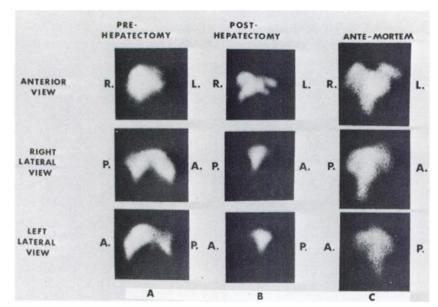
Typical technetium-sulfur colloid scintigraphs. Three views obtained (A) before partial hepatectomy. (B) immediately after partial hepatectomy, and (C) before sacrifice (in this case 22 days posthepatectomy). Note removal of anterior lobes is best seen in lateral views. R = right; L = left; A = anterior; P = posterior.
